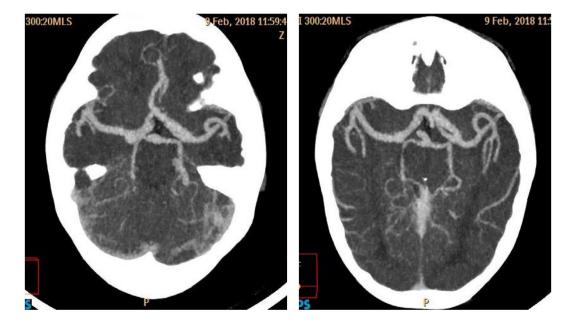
Computed tomography scan of brain showing giant circle of Willis
